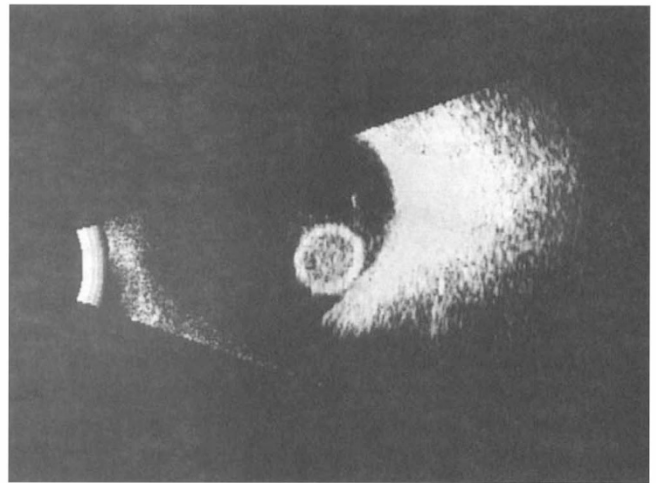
Previous B-mode ultrasound scan of the left eye shows the intact lens dislocated into the inferior vitreous cavity.
